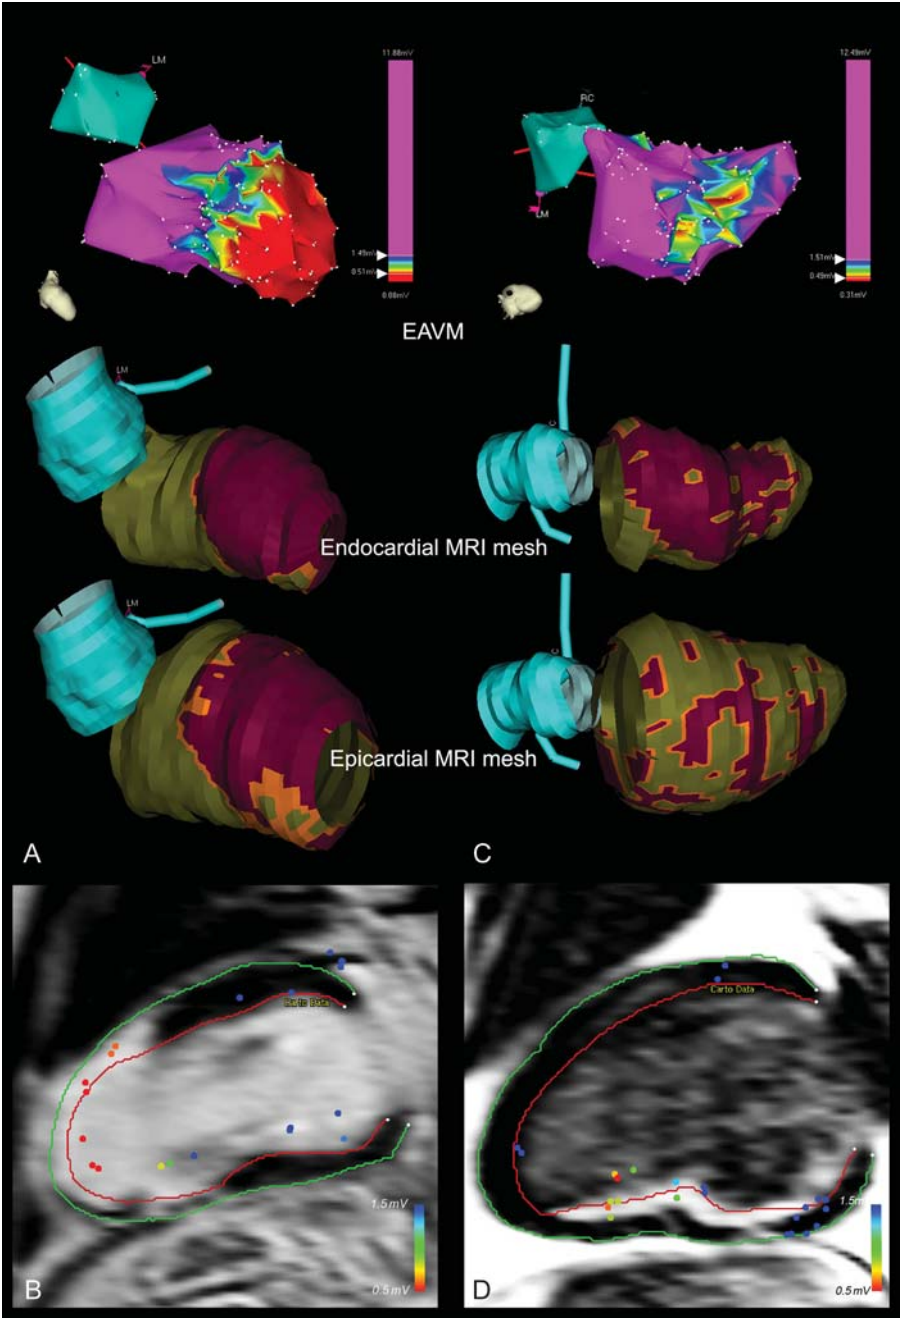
Representative examples of a patient in whom contrast-enhanced magnetic resonance imaging-derived mesh matched the electro-anatomical voltage mapping (A and B) and of a patient with additional scar areas identified by contrast-enhanced magnetic resonance imaging not detected by electroanatomical voltage mapping (C and D). (A and C) The bipolar voltage maps (colour coding as in the colour bar) and corresponding endo- and epicardial magnetic resonance imaging-derived surface meshes coded for transmural (purple represents scar and green represents normal myocardium). (B and D) A representative long-axis contrast-enhanced magnetic resonance imaging slice with superimposed mapping point locations (mapping point bipolar amplitudes are colour coded as in voltage maps).
